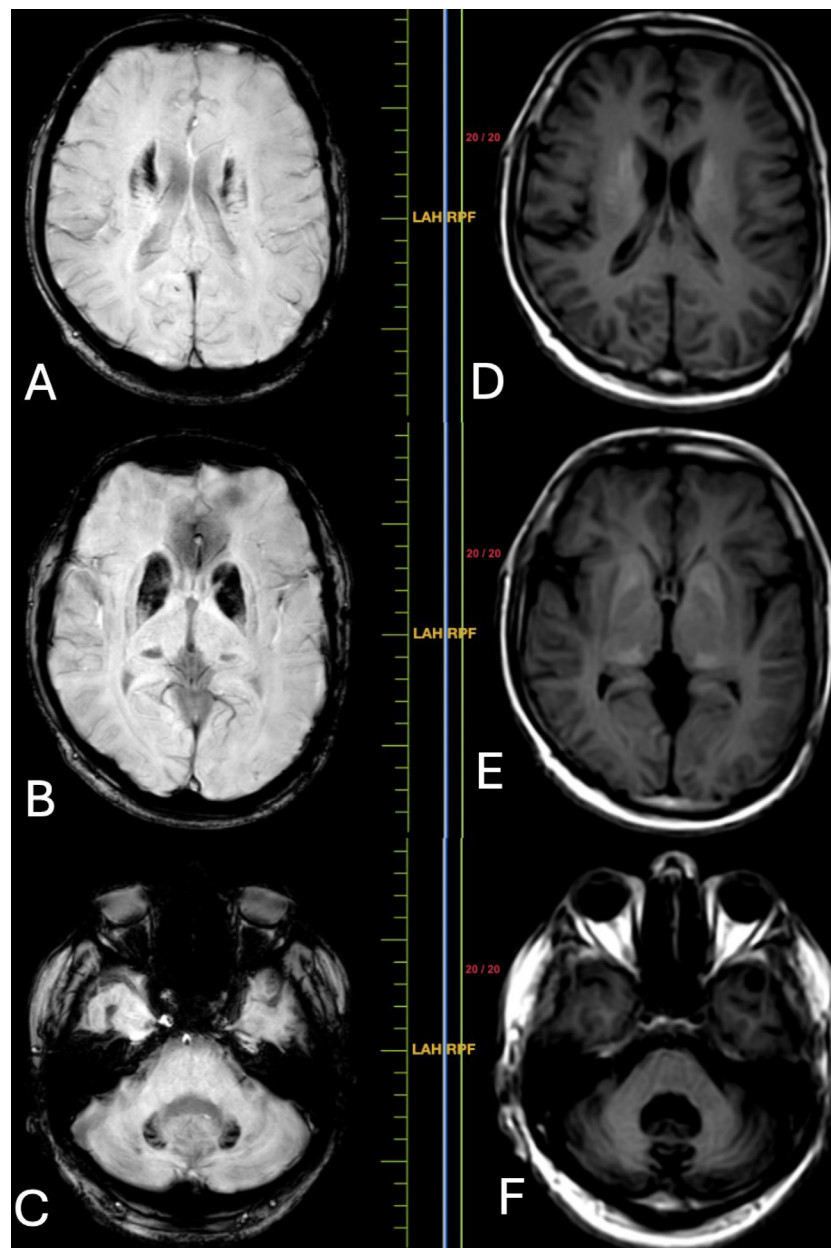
Brain magnetic resonance imaging axial sections of brain reveals altered signal alterations as blooming on susceptibility weighted imaging and hyperintensity on T1WI, consistent with calcifications in the same regions as identified in the computed tomography scan, particularly within the bilateral corona radiata (A and D), bilateral gangliocapsular region (B and E), bilateral thalamus (B and E), and bilateral dentate nucleus (C and F).
